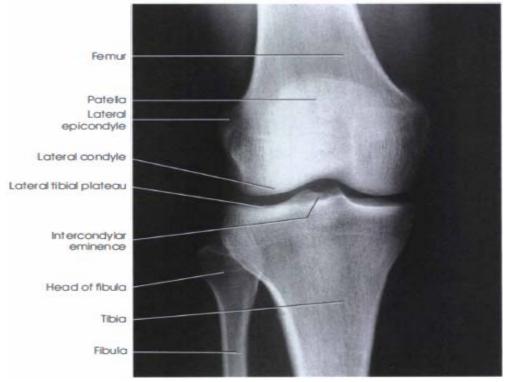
X-ray of the knee joint - AP view (Watts & Karadsheh, 2018).
